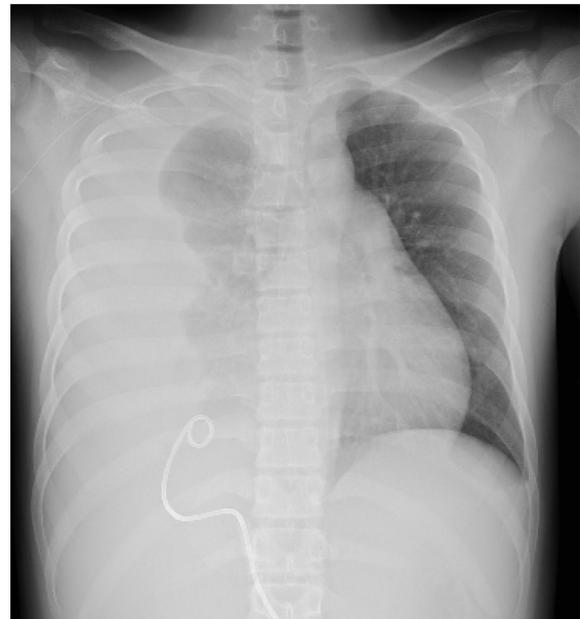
Chest X-ray showing pleural effusion on the right side on hospital day 19.
